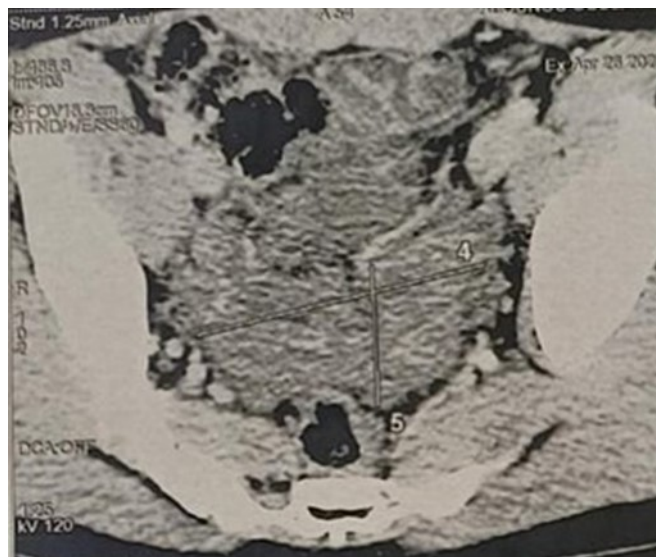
CT scan of the abdomen showing the hypogastric mass
